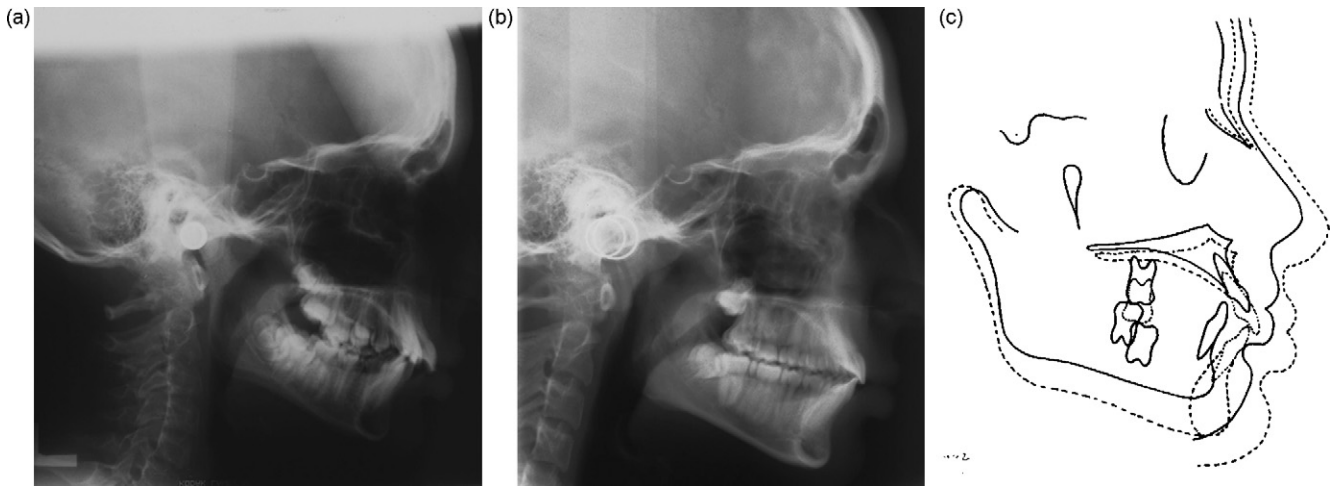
(A and B) Pre- and post-treatment radiographs of patient treated with the edgewise Herbst appliance showing the improvement in overjet and molar relationship. (C) Superimposition of radiographs before treatment and after 8 months of treatment with the Herbst appliance showing a restraint in forward maxillary growth and stimulation of mandibular growth.
